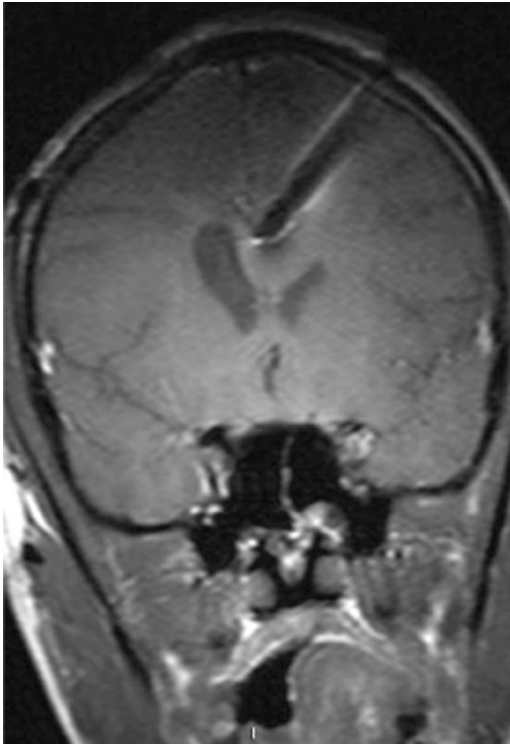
Coronal T1-weighted contrast-enhanced MRI scan after the MRI-compatible brain biopsy needle has been passed through the Navigus down to the target. The small enhancing focus that was found to be recurrent tumor is obscured by the artifact associated with the biopsy needle in this orientation. Alignment along B_0 when possible will delimit the metallic artifact. In this case, as the lesion was along the mesial aspect of the left hemisphere, a long axis approach might have likely injured vascular structures as the needle passed through multiple sulci
